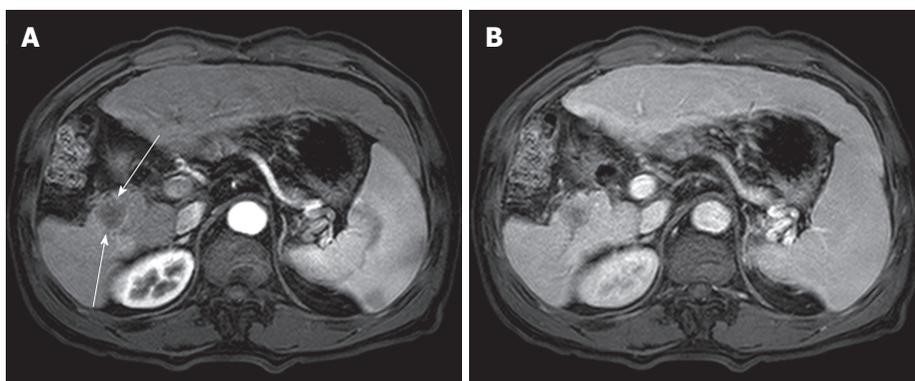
Computed tomography scan at follow-up of twenty-one months. A: A well demarcated low-attenuated round mass was newly found at the resection margin of right posterior segment (slender arrows). This mass was not significantly enhanced in late arterial phase; B: This mass was also not well enhanced at portal phase, which is similar pattern with the previous malignant fibrous histiocytoma.
